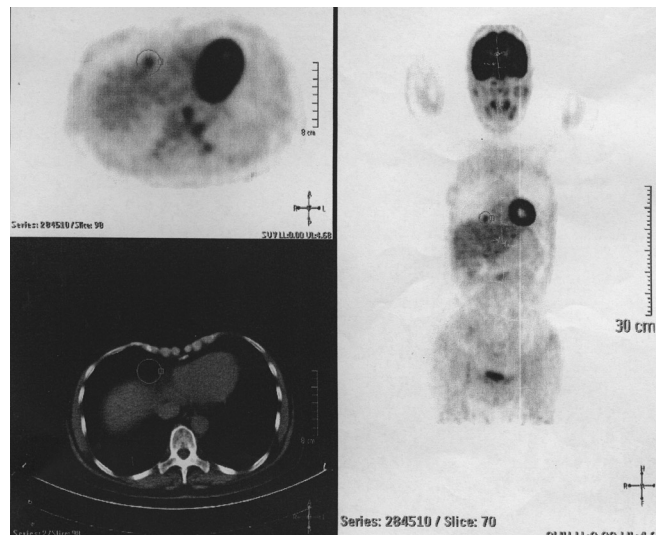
Axial CT-PET scan demonstrating the hepatic mass.
